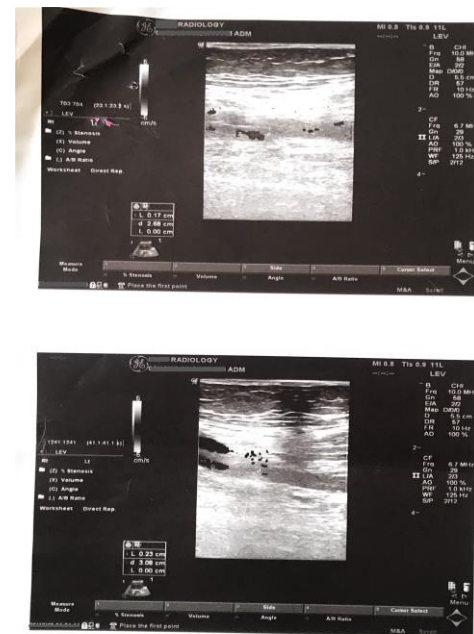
Duplex ultrasonography suggestive of chronic DVT
